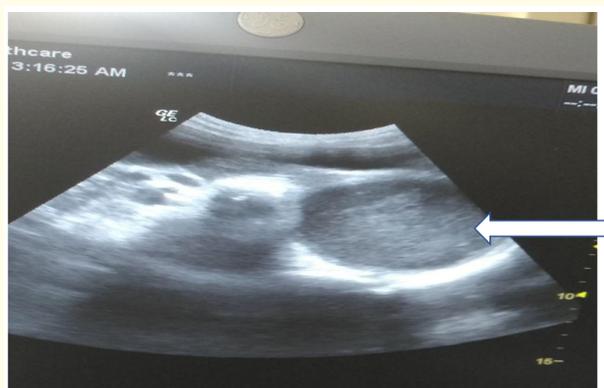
Transabdominal ultrasound showing hematometra seen by arrow above.
